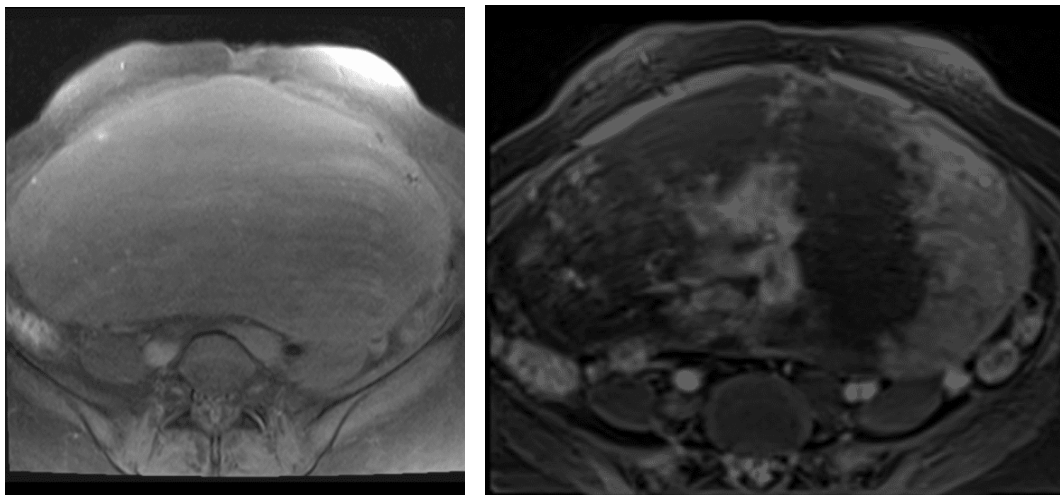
Post-contrast fat-suppressed T1-weighted images demonstrating heterogeneous enhancement corresponding to the areas of restricted diffusion.
